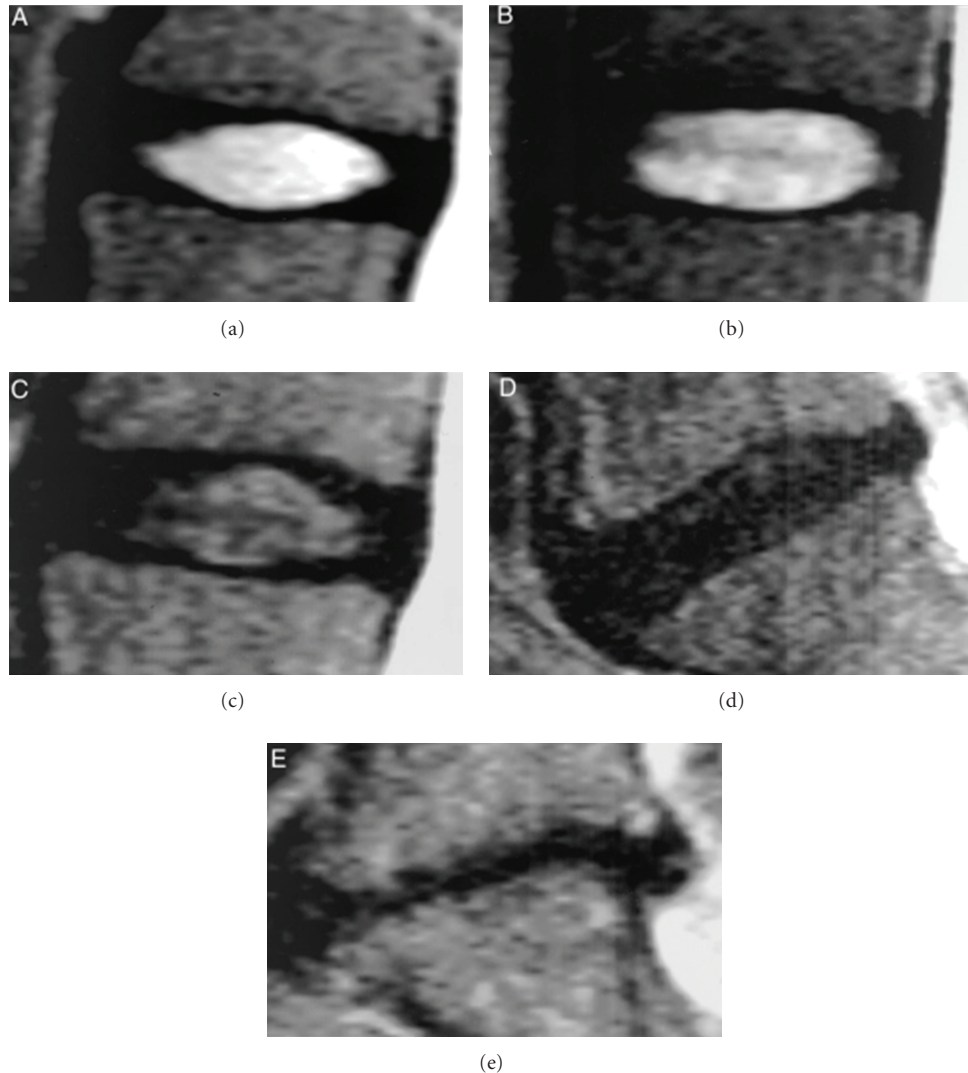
(a–e) pictures depict the grading system for the assessment of lumbar disc degeneration. Grade I: the structure of the disc is homogeneous, with bright hyperintense white signal intensity and a normal disc height. Grade II: the structure of the disc is inhomogeneous, with a hyper intense white signal. The distinction between nucleus and annulus is clear, and the disc height is normal, with or without horizontal gray bands. Grade III: the structure of the disc is inhomogeneous, with intermediate gray signal intensity. The distinction between nucleus and annulus is unclear, and the disc height is normal or slightly decreased. Grade IV: the structure of the disc is inhomogeneous, with hypointense dark gray signal intensity. The distinction between nucleus and annulus is lost, and the disc height is normal or moderately decreased. Grade V: the structure of the disc is inhomogeneous, with hypo intense black signal intensity. The distinction between nucleus and annulus is lost, and the disc space is collapsed. Grading is performed on T2-weighted midsagittal (repetition time 5000 msec/echo time 130 msec) fast spin-echo images [28].
